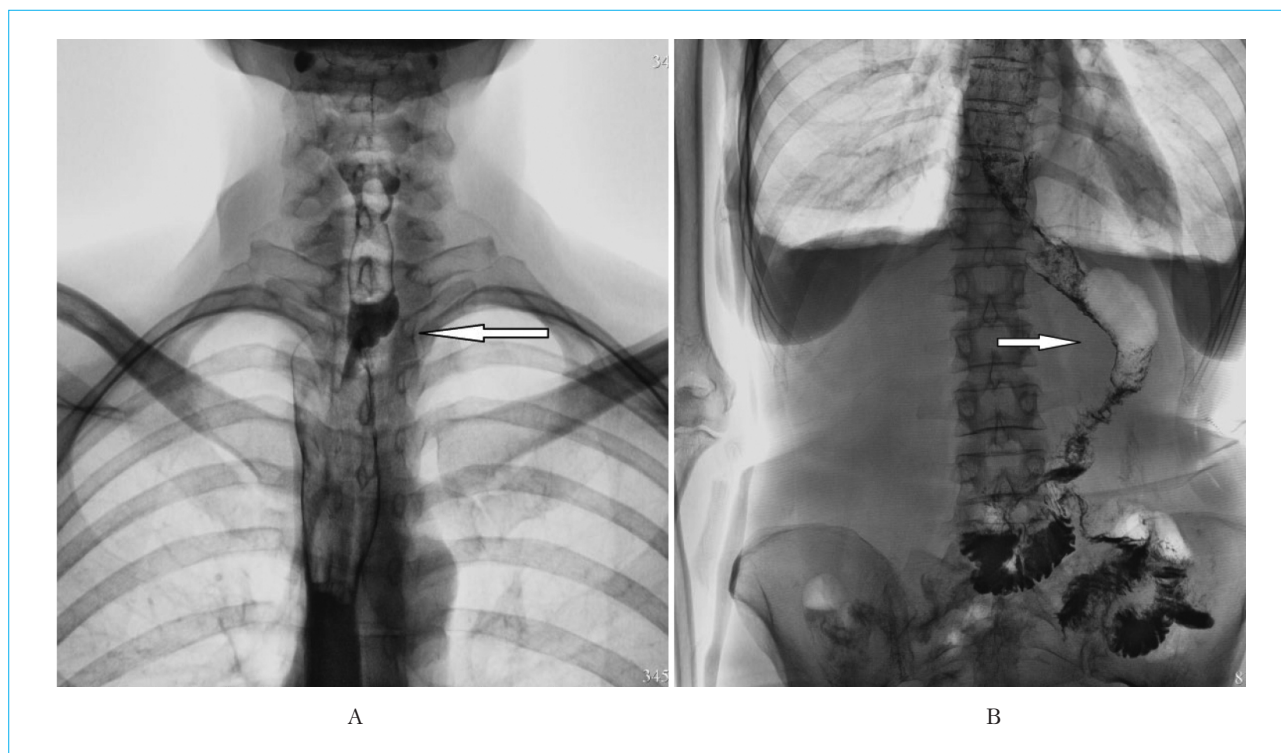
Radiographs of the gastrointestinal graft with oral administration of barium sulfate 3 years after surgery: the arrows indicate the esophageal anastomosis (A) and the jejunal segment (B)
